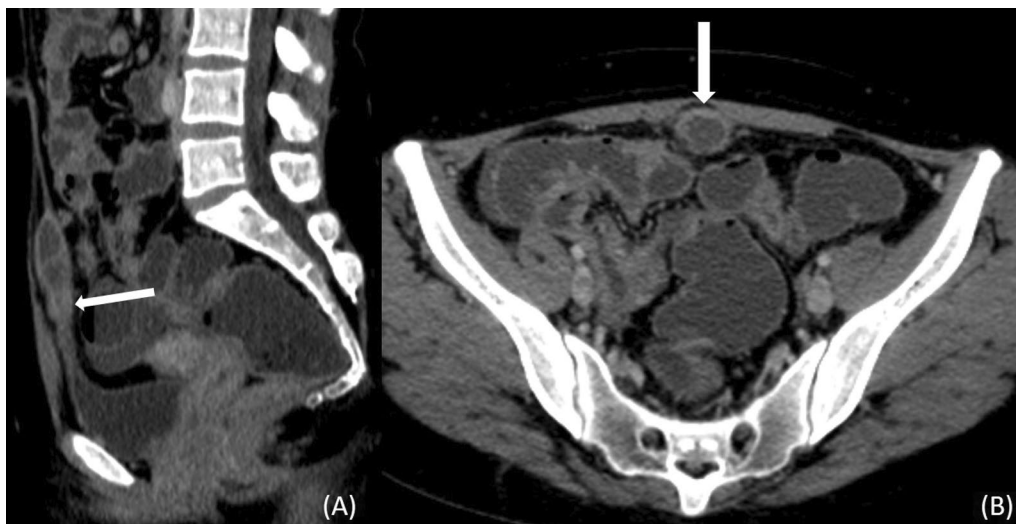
Tuberculosis of the urachal cyst. CT images of a 26-year-old female show irregular thickening and enhancement of urachal cyst wall (white arrow in A and B)
